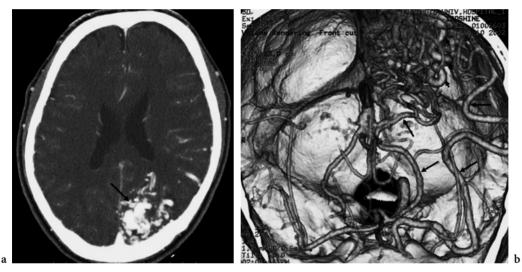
A 32-year-old man with left parietooccipital arteriovenous malformation. a Contrast-enhanced axial CT image shows abnormal enlarged vessels (*arrow*) in the parietooccipital region, which suggest cerebral arteriovenous malformation. b Volume-rendered CTA image from the front and above shows feeding arteries (*arrows*) from the middle and posterior cerebral arteries and draining veins (*arrowheads*).
